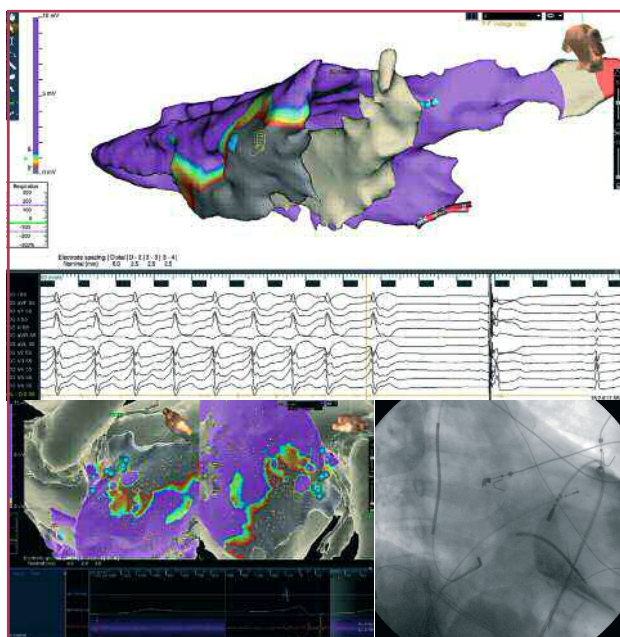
Top:* Epicardial voltage mapping delimiting the anterolateral region of the scar. The blue dots correspond to the effective ablation site (circuit isthmus). *Bottom:* Mid-diastolic potentials recorded by the ablation catheter placed in the circuit isthmus during sustained monomorphic ventricular tachycardia (yellow). Notice the prolongation of the ventricular tachycardia cycle before its interruption. *Bottom, left:* Fusion of multidetector computed tomography angiography and epicardial voltage mapping. The blue dots correspond to a slow conduction channel from the edge to the inside of the scar (double ventricular electrogram in red: ROV SC D2). Targeted focal cryoablation was performed to eliminate the conduction within the scar. *Bottom, right:* Right anterior oblique projection. Subxiphoid approach and fluoroscopic catheter position at the epicardial level, on the effective ablation site in the lateral left ventricular wall.
